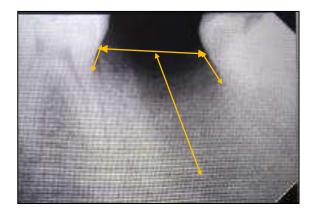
Height of bone- Pre operative radiograph with Arrows showing Central, mesial and distal linear measurements
